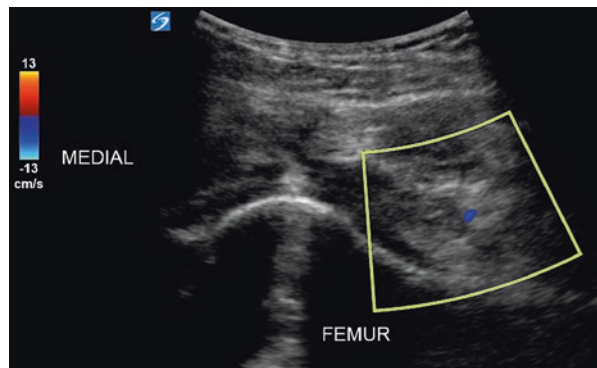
Ultrasound scan over the anterior recess. (Reprinted with permission from Dr. Agnes Stogicza)
